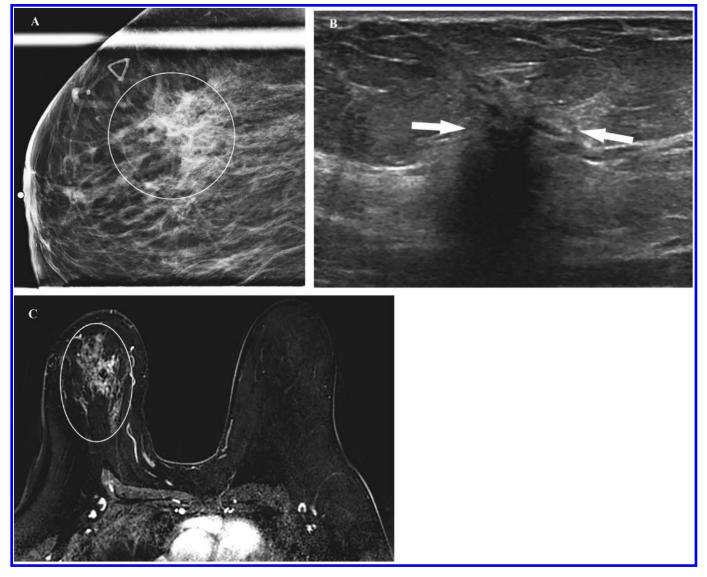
A 57 year-old female presenting with palpable lump in the right breast. Biopsy pathology was ductal carcinoma *in situ*, intermediate to high grade, and final pathology yielded microinvasive carcinoma. (A) Mediolateral spot compression mammogram of the right breast demonstrates a focal asymmetry (white circle). Triangular skin marker indicates a palpable abnormality is present at this site. (B) Grayscale sonographic image shows an irregular mass with indistinct margins at the 12 O'clock axis, site of palpable abnormality (white arrows). (C) Axial dynamic contrast-enhanced T_1 weighted subtraction image of the right breast shows regional asymmetric non-mass enhancement (white circle).
